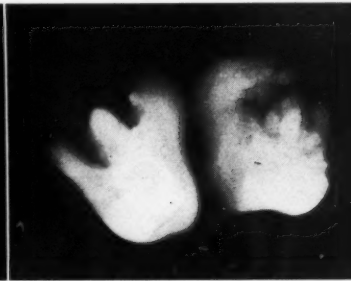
Roentgenogram of mass after separation, showing teeth.
